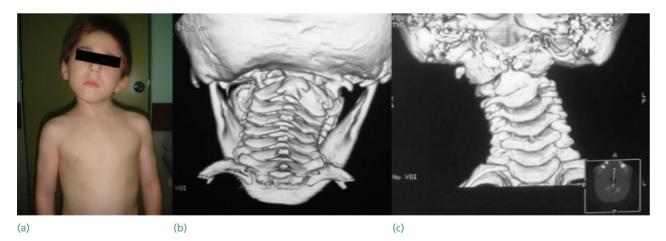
Congenital torticollis (a) Clinical picture of a young child with congenital torticollis. Note the head tilting towards the left shoulder with slight rotation to the contralateral side. (b,c) 3D reconstruction of CT images of the same child showing atlantoaxial fusion.
